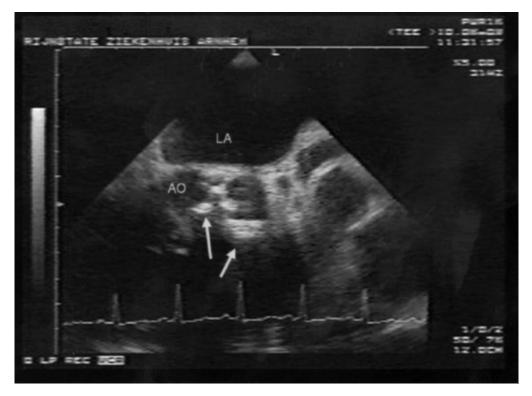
Transoesophageal echocardiogram showing two round echodense lesions on the aortic valve of patient A.
